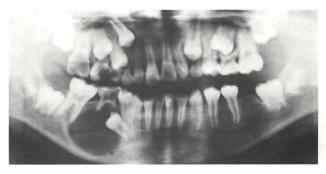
Panoramic radiograph of Case 3 shows a pattern highly suggestive of dentigerous cyst.
